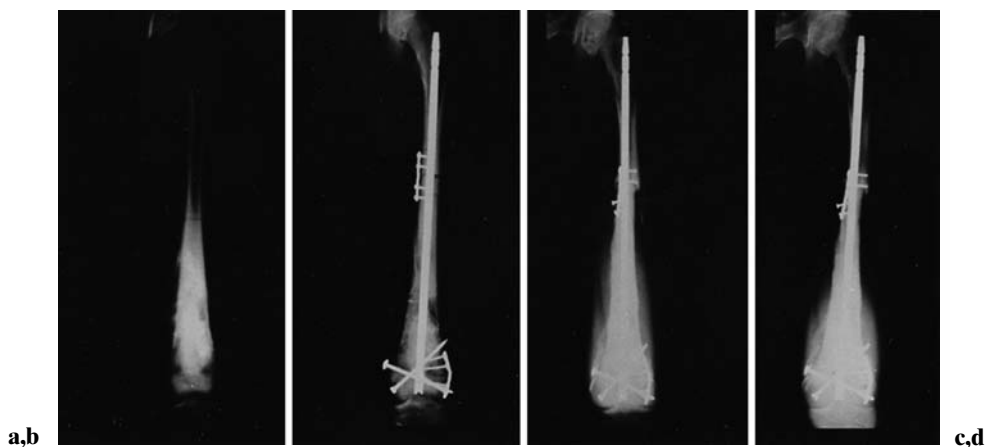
Anteroposterior radiographic features of the left femur before and after surgery. a Before surgery. b Immediately after initial surgery. c Two months after surgery. d Two years after surgery. Wide excision and reconstruction with an autoclaved autograft was performed during the initial surgery. At the distal site satisfactory bone formation and fusion was observed on the radiograph, whereas at the proximal site bone fusion was poor and nonunion finally developed
